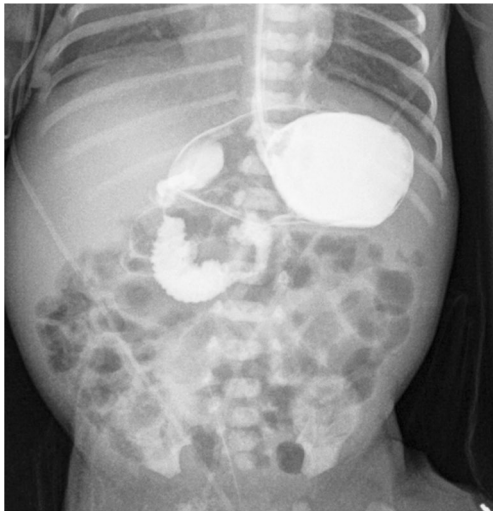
Image in an 8-day-old male, 31 weeks' gestational age. A 1-min radiograph from a bedside UGI study demonstrates an apparent low and medially positioned DJJ. Transverse positioning of the stomach and patient rotation precludes accurate interpretation of the DJJ position. A formal UGI series performed with barium demonstrated a normally positioned DJJ
